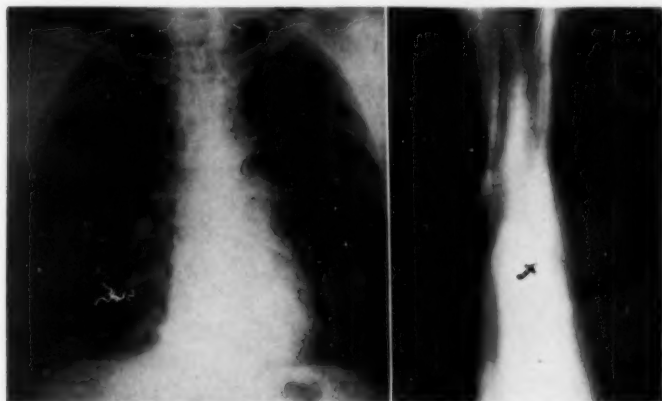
To left, roentgenogram appearing essentially normal, in patient with adenoma of cylindroma type located in left main bronchus. At right, planigraphic film showing obstruction of main bronchus produced by tumor. This patient has remained symptomatically well but requires palliative treatment at intervals of several months. Surgical consultant does not advise pneumonectomy, because of the fact that the tumor is located at the carina. (H. S., male, age 45, cylindroma, Case 4).
